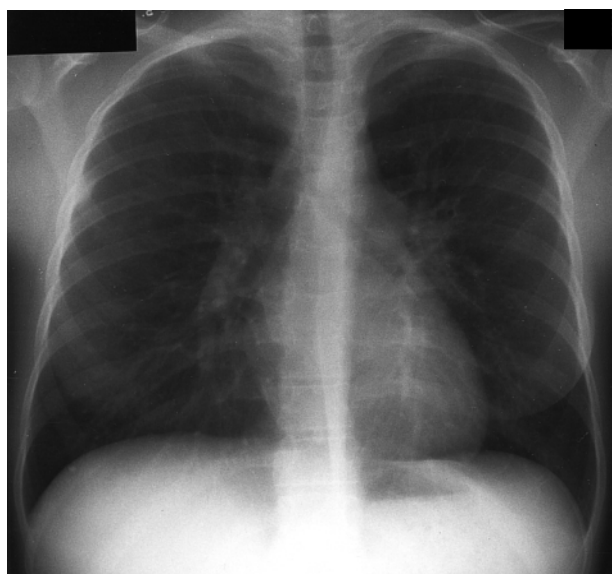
Chest radiograph showing mediastinal lymphadenopathy causing displacement of the trachea to the right side in case no. 1.
